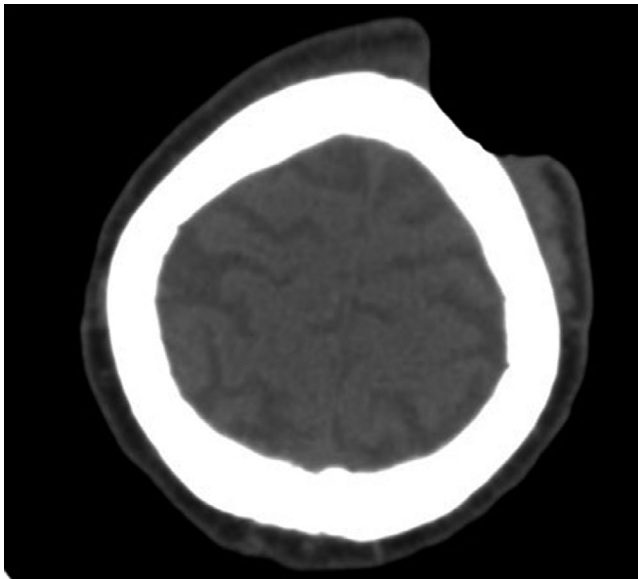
CT scan showing a large defect in the scalp but not involving the bone
